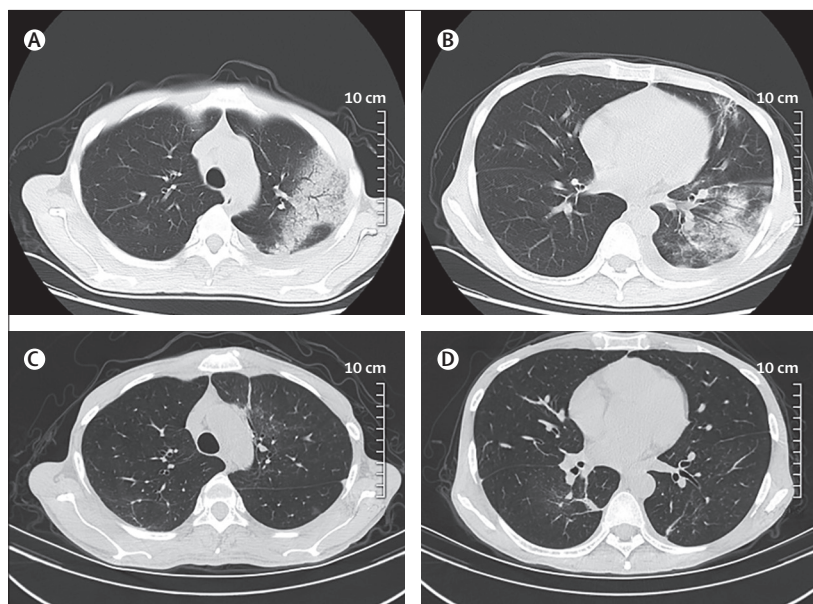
CT scan of the chest on day of admission and 2 weeks later. Upper lobe (A) and lower lobe (B), showing bilateral ground-glass opacities, mass-like high-density shadow in left lung with partial consolidation, patchy high-density shadow in the right lung, and a small amount of fluid in the left pleural cavity; upper lobe (C) and lower lobe (D), showing a substantial improvement with a marked reduction of pulmonary exudative lesions.
